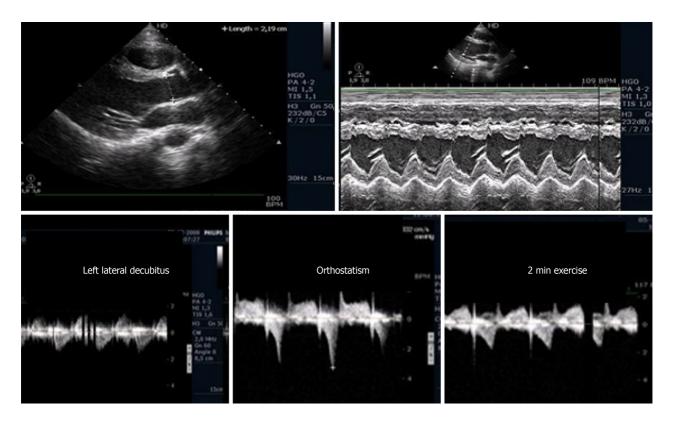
Intraventricular gradient present in the orthostatic position before exercise in an athlete, decreased during the initial phase of exercise testing. Citation: Cotrim C, João I, Fazendas P, Almeida AR, Lopes L, Stuart B, Cruz I, Caldeira D, Loureiro MJ, Morgado G, Pereira H. Clinical applications of exercise stress echocardiography in the treadmill with upright evaluation during and after exercise. Cardiovasc Ultrasound 2013; 11: 26. [PMID: 23875614 DOI: 10.1186/1476-7120-11-26] Copyright © The Author (s) 2013. Published by BMC part of Springer Nature.
